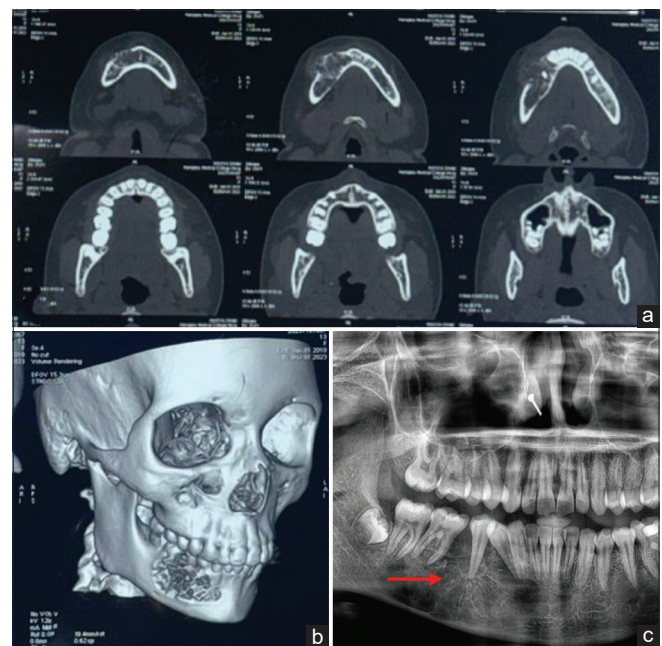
(a) Buccolingual expansion seen on the right mandibular region. (b) 3D reconstructed CT showing lesion extending from 43 to 46 region. (c) Sunray appearance seen in relation to 45 extending towards 46 and 44 region
